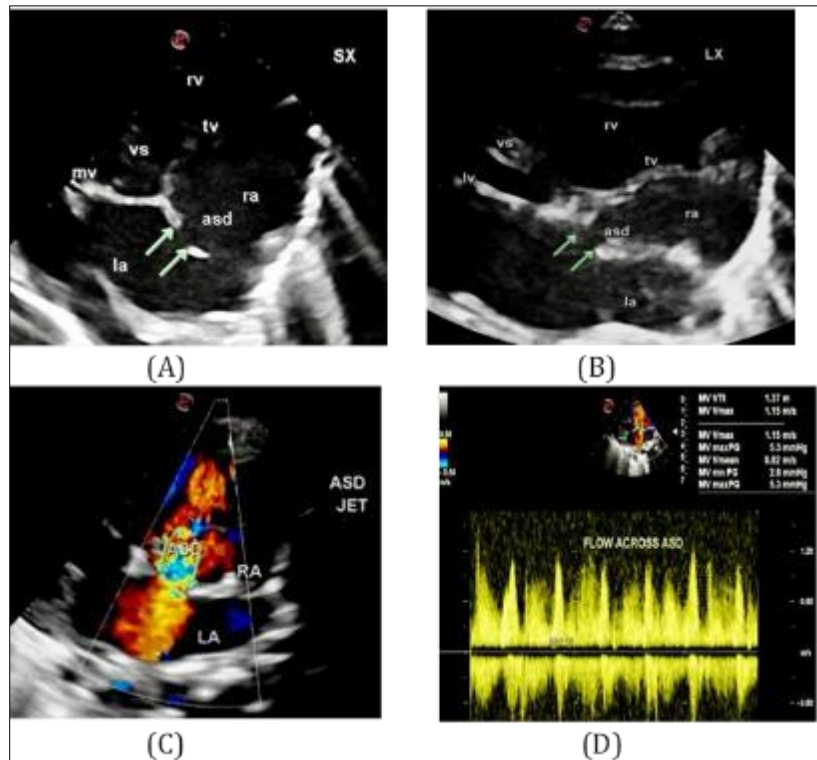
2-Dimensional Transthoracic Echocardiography: (A) SX View shows a moderate size ostium secundum ASD. (B) LX view reveals the same ASD. (C) Color Echocardiography shows a turbulent mosaic pattern jet across the ASD. (D) Pulse wave doppler (PWD) across ASD depicts a peak and mean gradient of 5.3/2.8 mmHg
